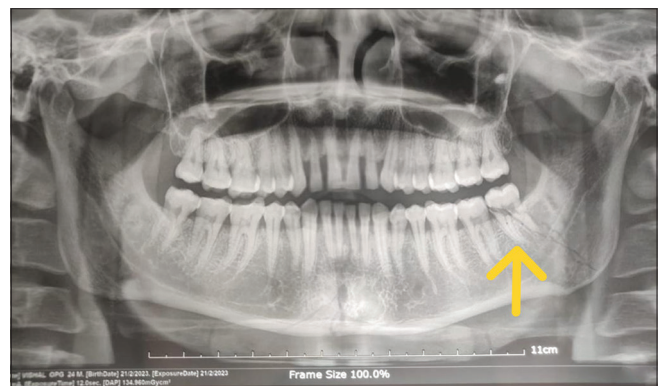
Orthopantomogram showing both mesial and distal root fractures in mandibular third molar marked with an arrow
